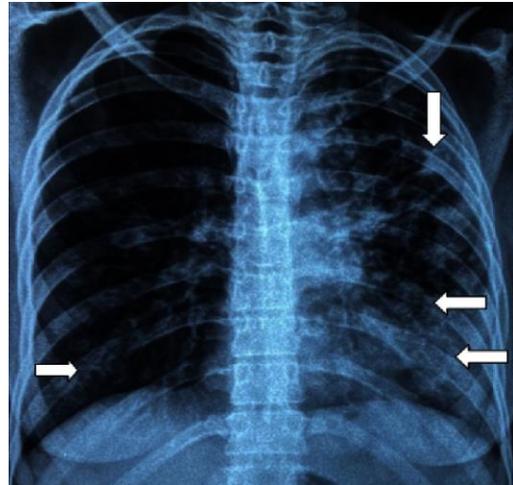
Chest X-ray of the patient on the first day.
